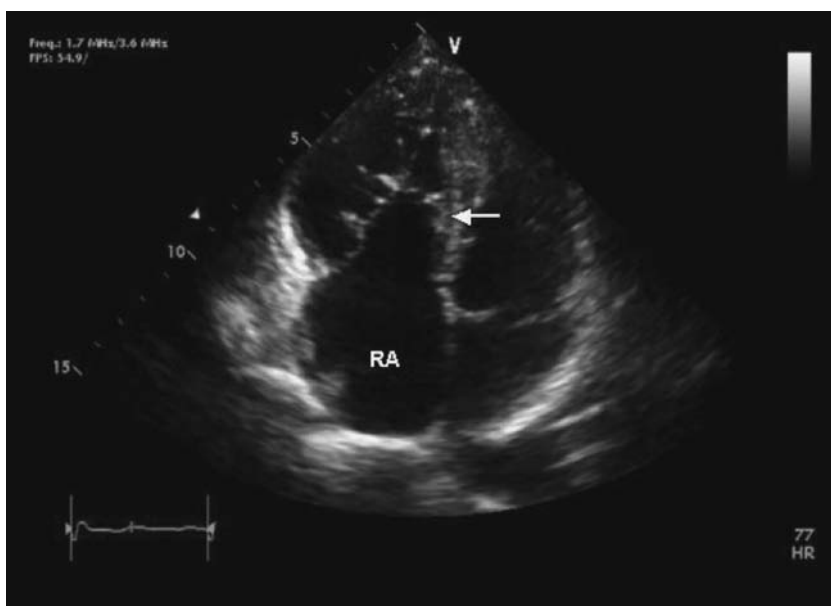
Transthoracic echocardiogram apical four-chamber view of Ebstein anomaly demonstrating apical displacement of the septal leaflet of the tricuspid valve (arrow) and an enlarged right atria due to atrialization of the left ventricle. RA, right atrium.
